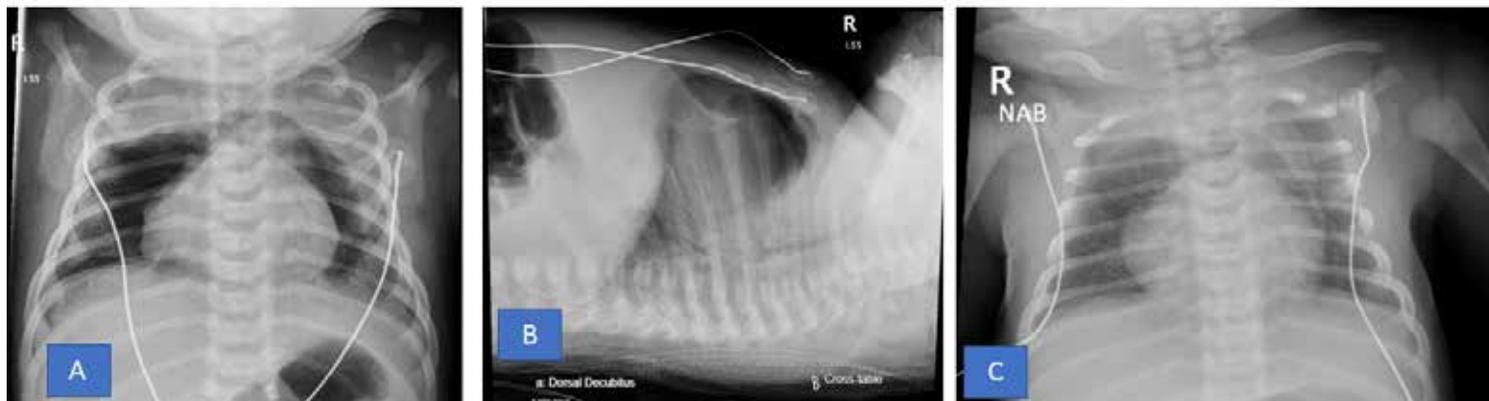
A: Chest x-ray, AP view, with significant pneumomediastinum; Figure 1 B: Chest x-ray, cross-table lateral view, with significant anterior pneumomediastinum; Figure 1 C: Chest x-ray, AP view, with significant resolution of pneumomediastinum
